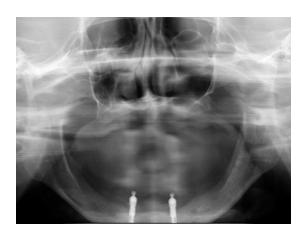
Pre-surgical orthopantomography.
